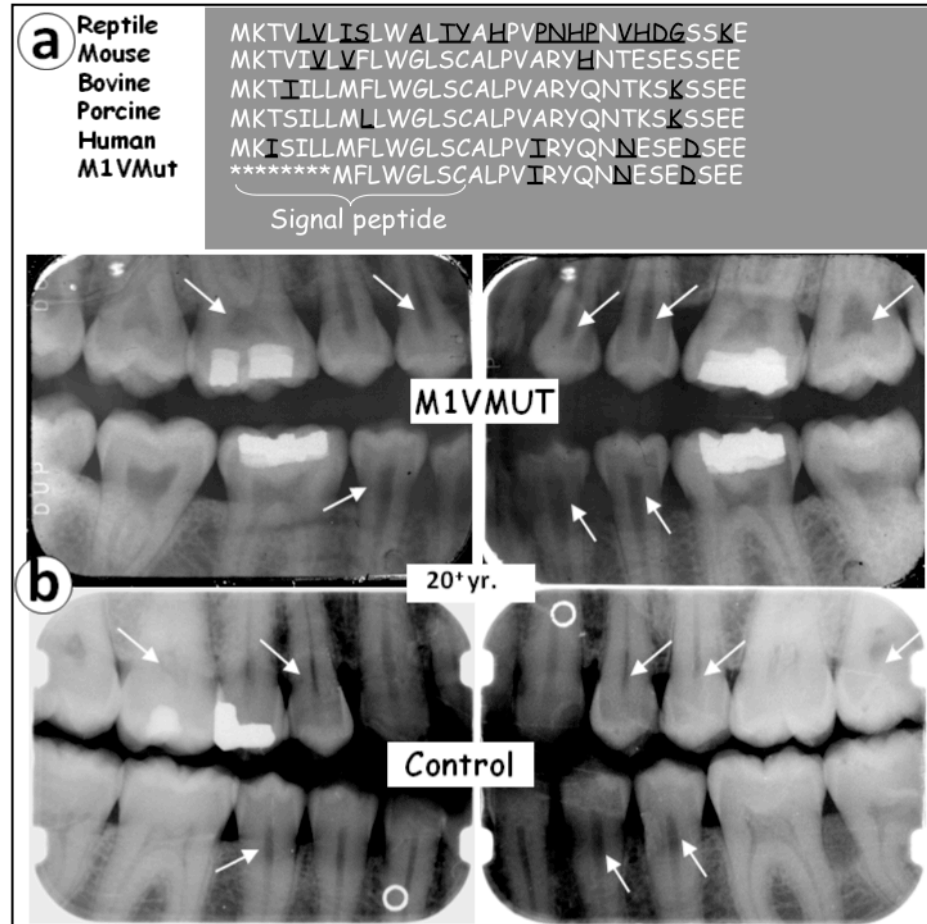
Tooth phenotypes in an M1V Mut ARHR patient. (a) Comparison of the amino acid sequence of the NH₂-terminal region of the DMP1 across species, including the M1V mutant human DMP1. (b) Radiographs from an adult (20+ years old) ARHR patient (upper panel) and the age-matched control (lower panel). Arrows show the enlarged pulp cavities and root canals and reduced dentin thickness in the patient, compared to the control.
